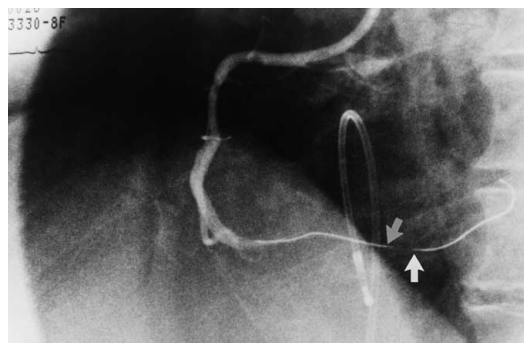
Both the Doppler guidewire and the pressure guidewire were placed distal to the stenosis. The sample volume of the Doppler guidewire was located 5 mm distal from the tip of the wire (closed arrow). The transducer of the pressure guidewire (open arrow) was placed at the same position as the Doppler sample volume.
